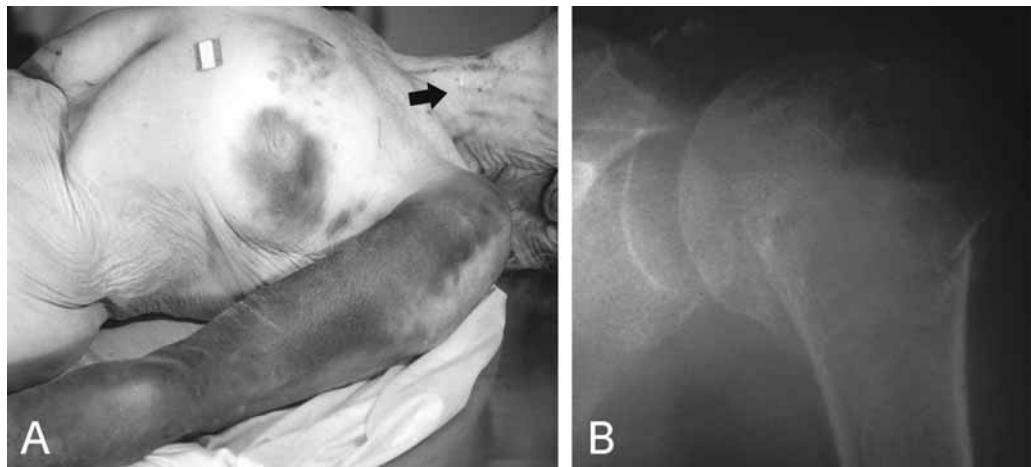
Elderly woman found dead outdoors from hypothermia (see Fig. 5). (A) Extensive extravasation of blood in left arm and forearm from fractured humerus sustained 2 wk prior to death. Neck abrasions (arrow) raised the possibility of strangulation. There were no external petechiae. Internal neck trauma was absent. (B) Fracture of humerus demonstrated in postmortem radiograph.
